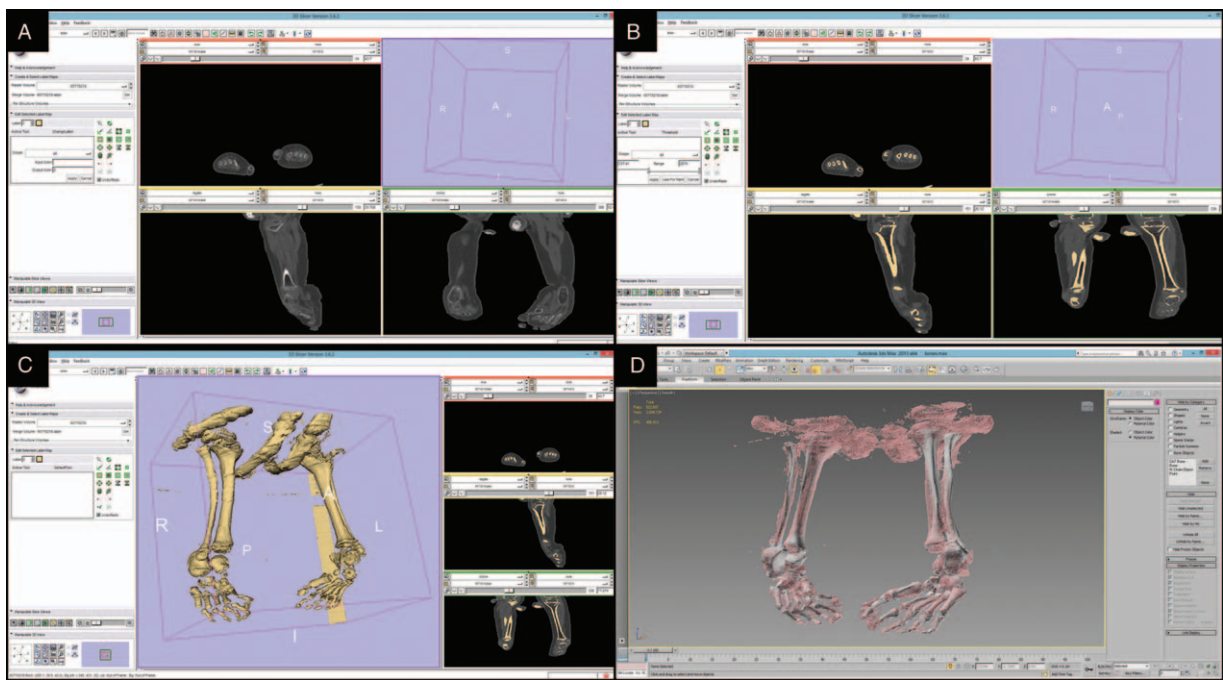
Generation of the 3D model for computer modeling. (A) Introduction of DICOM model from CT imaging data using 3D Slicer processing tool; (B) processing of DICOM files; (C) 3D Studio Max processing. DICOM = Digital Imaging and Communications in Medicine.
